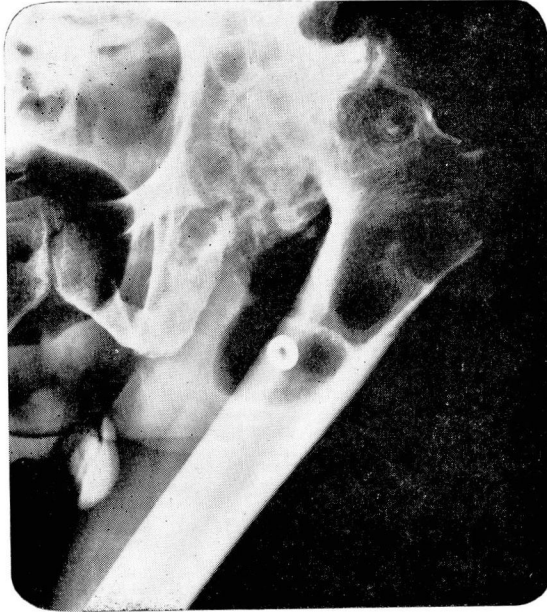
Plain roentgenogram of the left hip. Note evidence of gas-filled area in region of proximal femur.
